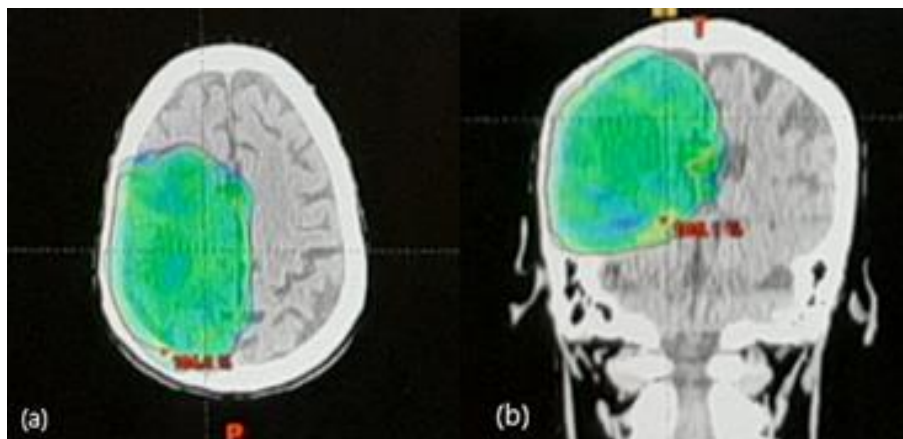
axial (a) and coronal (b) computed tomography scan dosimetry showing a conformal dose distribution (isodose 95%) by RapidArc
